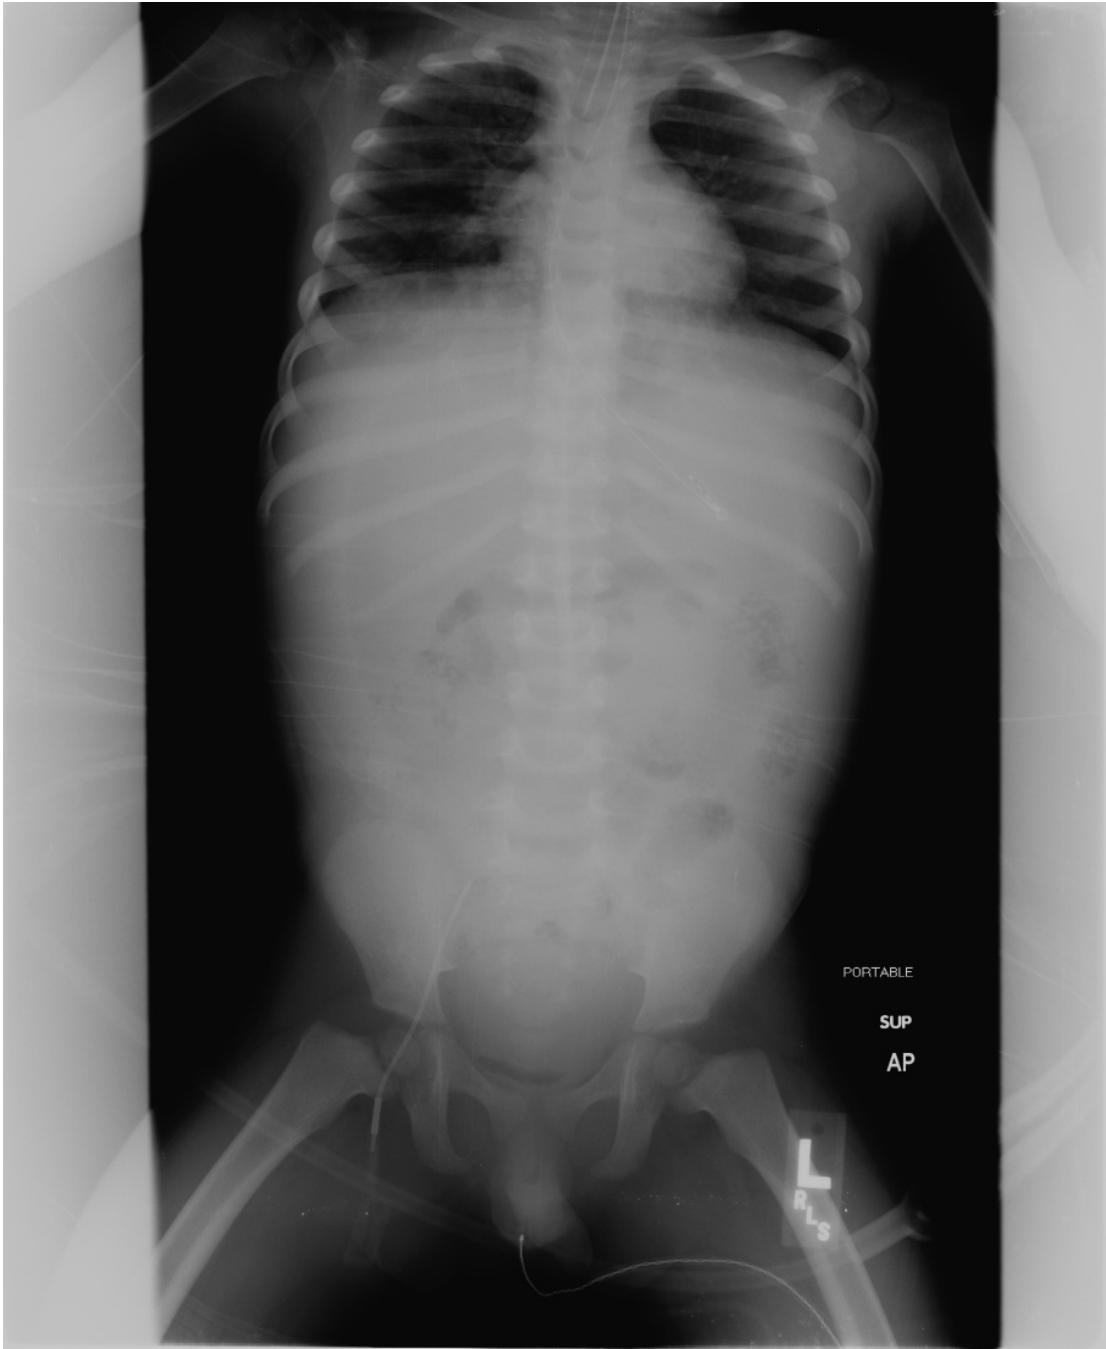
The classic “football sign” with air outlining the falciform ligament and filling the abdomen. Note that the radiograph should always get whiter, indicating an increase in density, when moving from lateral to medial over the liver, and that this radiograph violates this rule.
